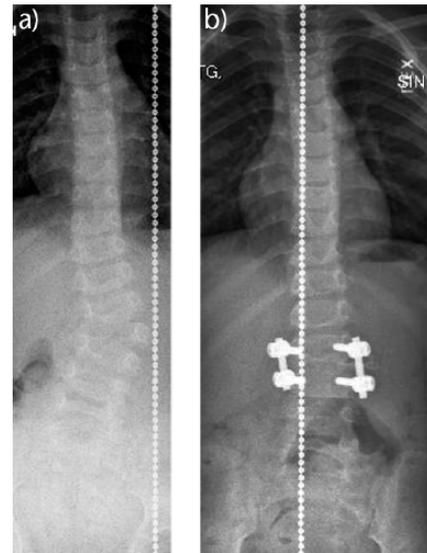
a) Standing spinal radiograph demonstrating a fully segmented lumbar hemivertebra at the age of two years; b) standing radiograph two years after all posterior hemivertebrectomy and short 'single' level pedicle screw instrumentation.
